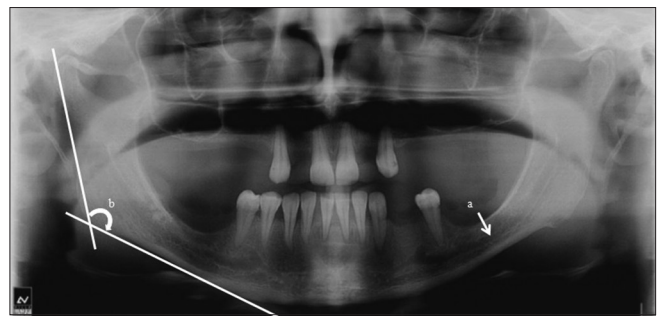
a - Gonial angle measurement. The measurement site in the radiograph was determined to be a point on the mandibular border at the intersection of a line tangential to the most inferior points at the mandibular angle and the lower border of the mandibular body, and a line tangential to the posterior borders of the ramus and the condyle; b - mandibular canal wall resorption
